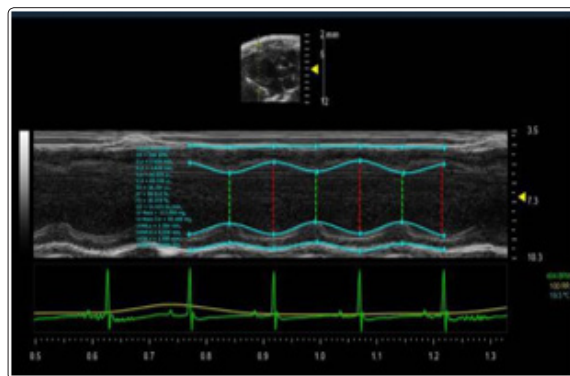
M ultrasound in the model group on the 10 day after stem cell intervention was normal
